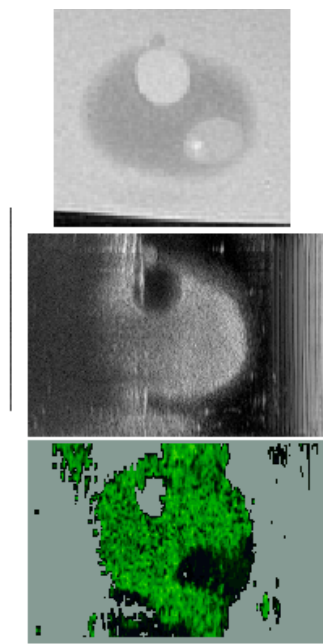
MRI (top), ultrasound (middle) and Sonoelastography (bottom) images.
